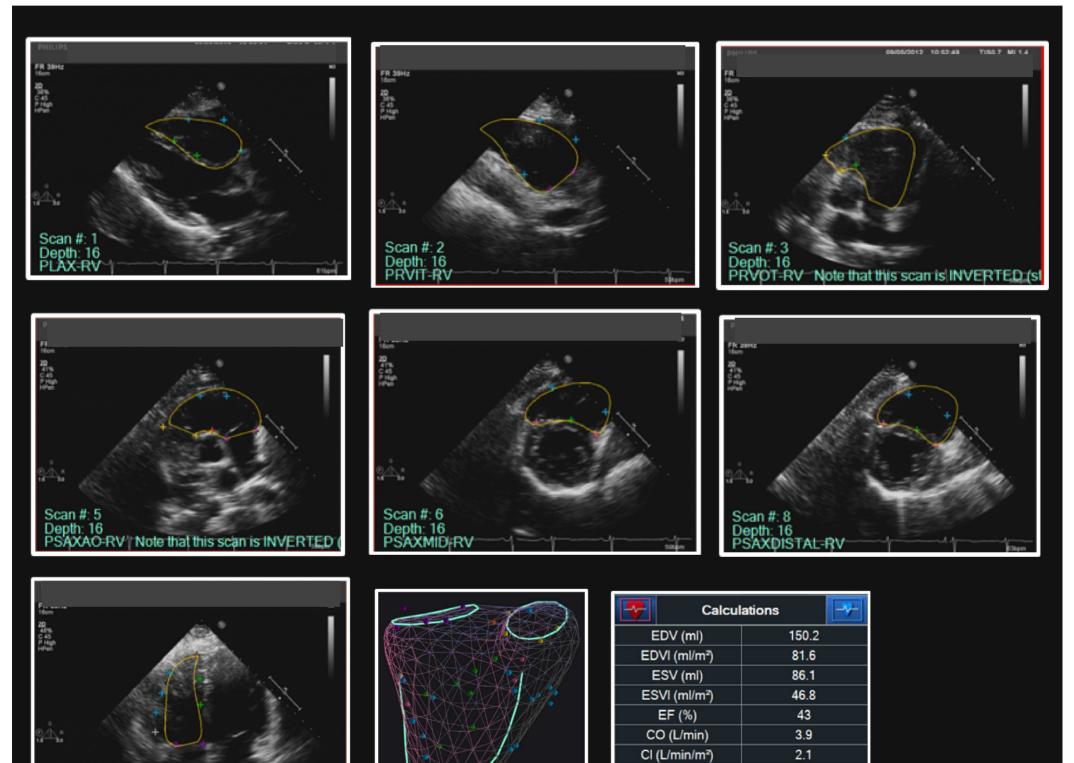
Views showing few anatomical landmarks identified. Parasternal Long Axis with two RV septal points and three endocardial points (A), Right Ventricular Inflow Tract with two RV annulus points and three endocardial wall points (B), Right Ventricular Outflow Tract with two pulmonary annulus points, one RV Septal point, and one RV endocardial point (C), Parasternal Short Axis with two TV annulus points, two pulmonary annulus points, one Conal Septal point, and two endocardial points (D), Parasternal Short Axis Mid RV with one septal point, two RV septal edge points, and two endocardial points (E), Parasternal Short Axis Distal RV with one Septal point, two RV Septal edge points, and two endocardial points (F), Apical 4 Chamber-RV with two TV annulus points, one basal bulge point, two endocardial points, two septal points, and one apical point (G).
